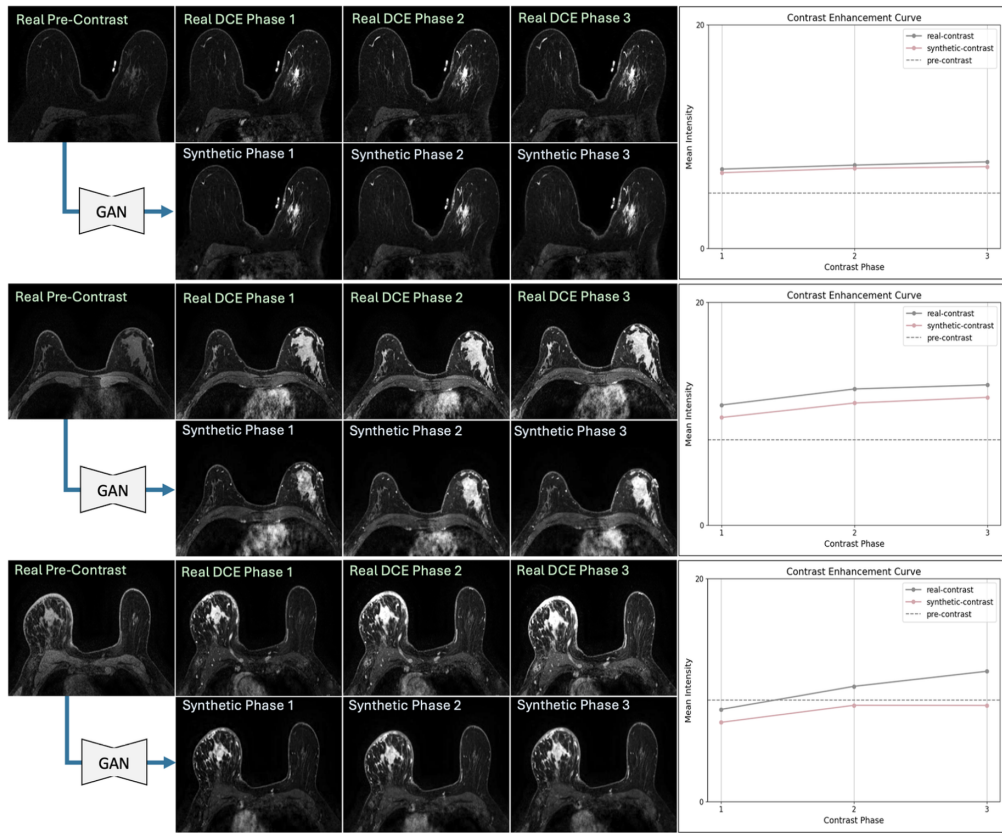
Qualitative results of joint multi-sequence DCE-MRI generation shown for three test cases with real images in each first row and respective synthetic images displayed in each second row. A single conditional GAN was trained to translate all test cases from pre-contrast to all three DCE-MRI sequences. Contrast enhancement curves are also shown, visualizing changes in image intensity across consecutive temporal DCE-MRI sequences for both real and synthetic data.
